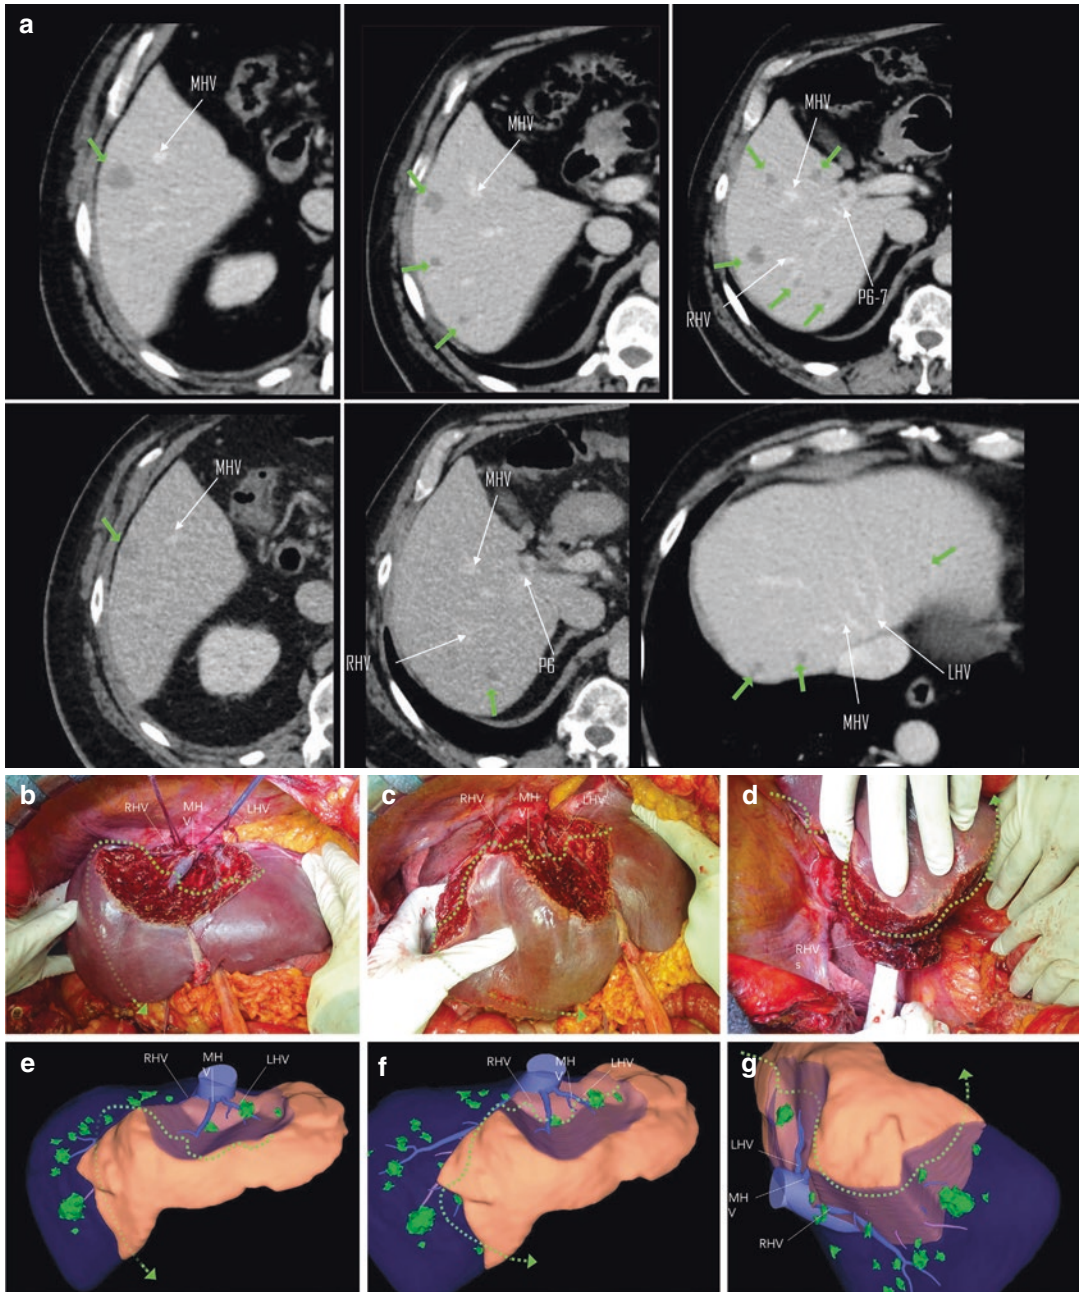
(a) Preoperative CT scan showing multiple bilobar colorectal liver metastases (marked by green arrows). Two major clusters in right posterior section are visible (b–d). Intraoperative images and comparison with the three-dimensional reconstruction (e–g). The green-dotted arrows indicate the transection plane. The three
